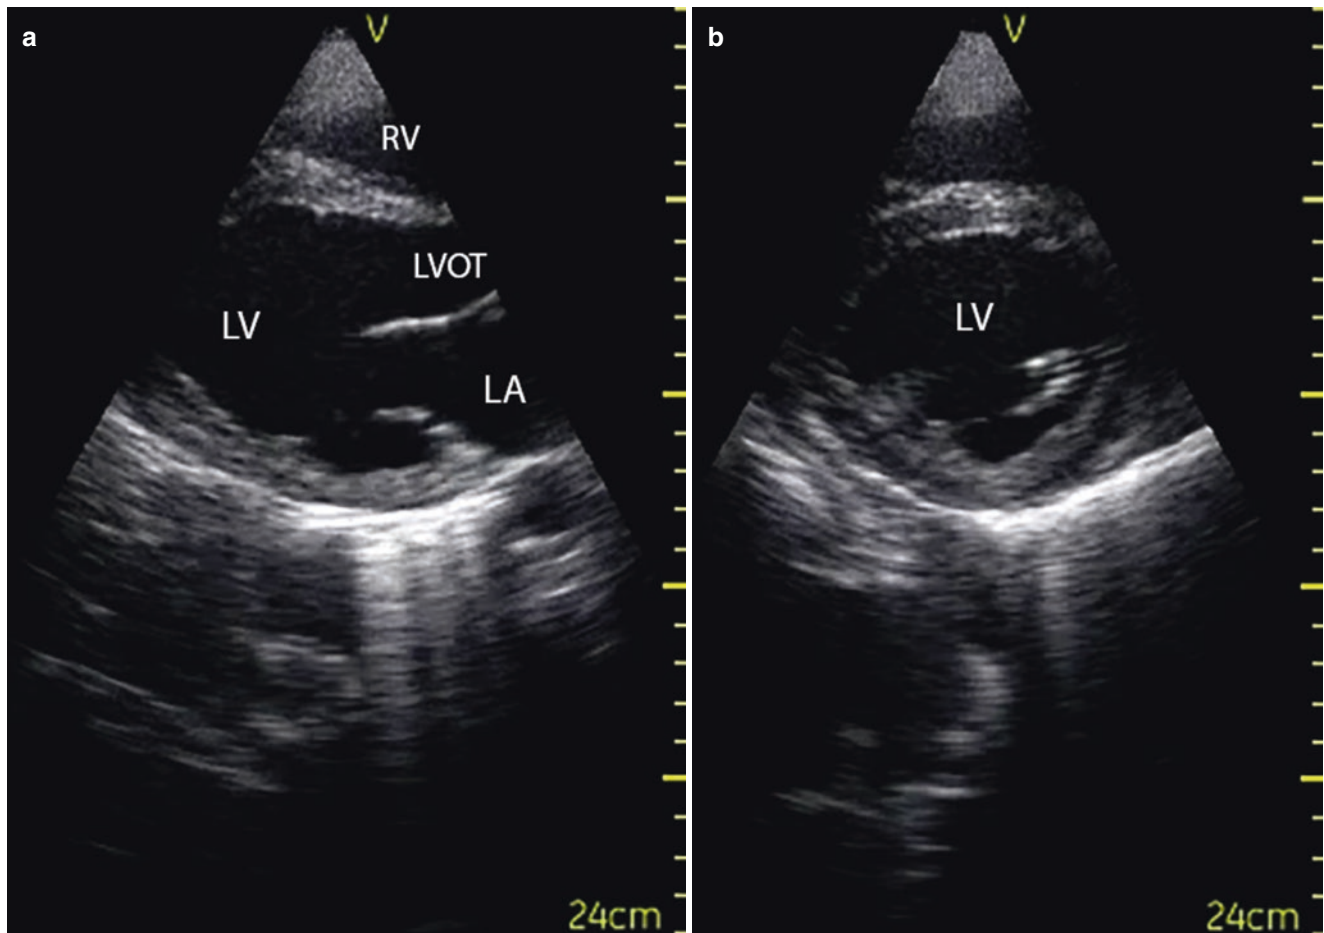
(a) Still image of the parasternal long axis to demonstrate anatomic landmarks in Video 17.3a (*LV* left ventricle, *RV* right ventricle, *LVOT* left ventricular outflow tract, *LA* left atrium). (b) Still image
